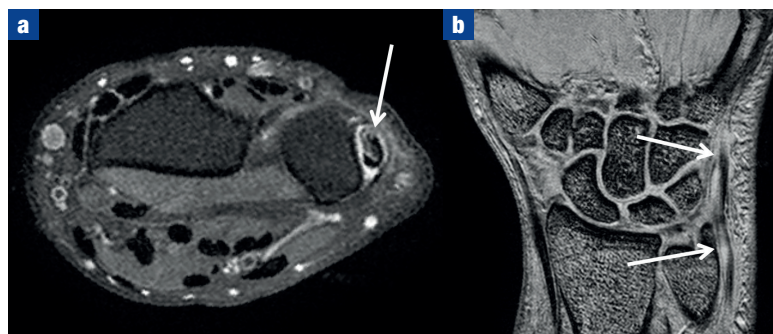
Magnetic resonance image short tau inversion recovery (STIR) sequences of the wrist (a) axial and (b) coronal demonstrate high signal fluid in the extensor carpi ulnaris tendon sheath (arrows) consistent with tenosynovitis. There is also high signal within a thickened extensor carpi ulnaris tendon as a result of an interstitial tear.
